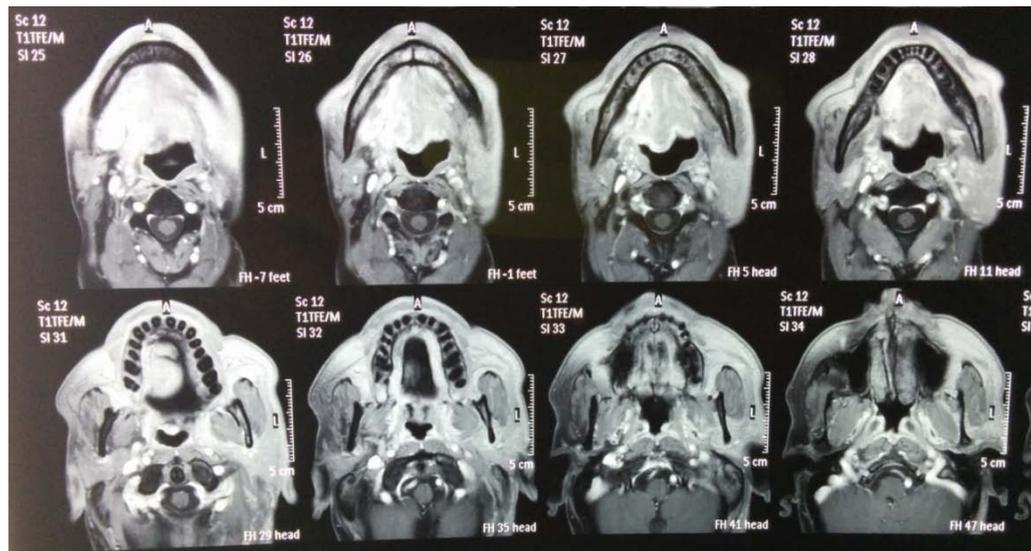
MRI Report Before Treatment:3rd May 2013
